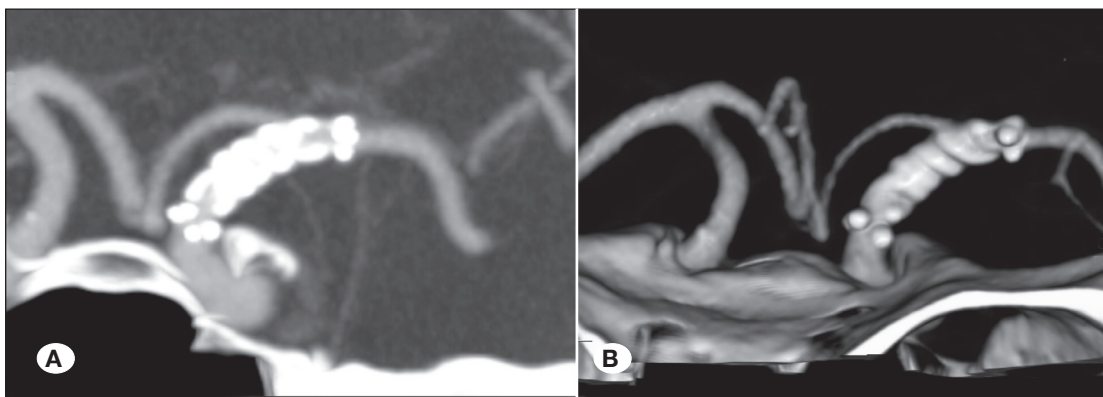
A CT angiogram at 24-month follow-up, MIP view (A), and 3D VR (B), showing correct FDS positioning and complete exclusion of the aneurysm. The CT angiogram also showed left A1 patency and narrowing.
